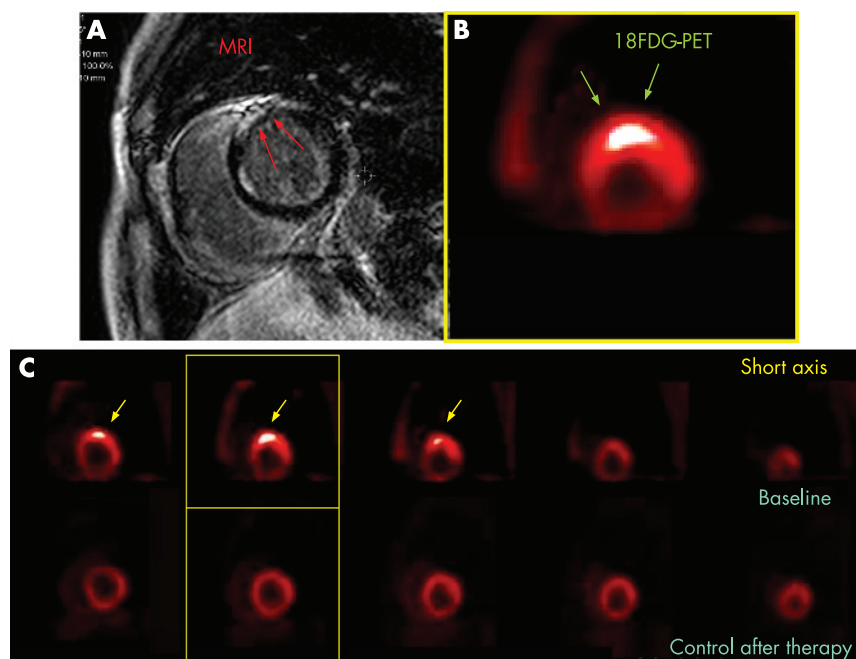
(A) Gadolinium-enhanced MRI scan of the heart (short axis) showing delayed enhancement in the anteroseptal myocardium. (B) ¹⁸F-FDG positron emission tomography (PET) scan of the heart (short axis) showing focal uptake in the anteroseptal wall (same location as MRI scan) corresponding to granulomatous inflammation. (C) ¹⁸F-FDG PET scan of the heart (short axis) from the base to the apex (from left to the right) showing focal uptake in the anteroseptal wall at baseline (upper series) and disappearance of the uptake after treatment (lower series). Images marked in yellow correspond to the MRI image in (A).
